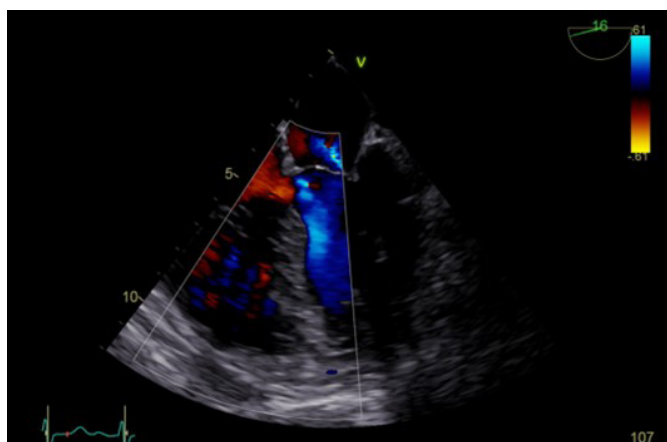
Mid-esophageal four-chamber view with color Doppler demonstrating left-to-right shunt at the basal level of the interventricular septum.
